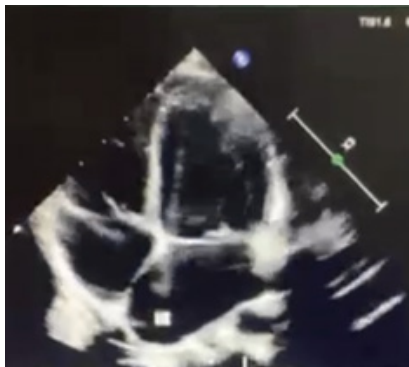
Pre-surgical transesophageal echocardiogram with a 4-chamber projection showing (blue arrow) an ostium secundum interatrial communication
